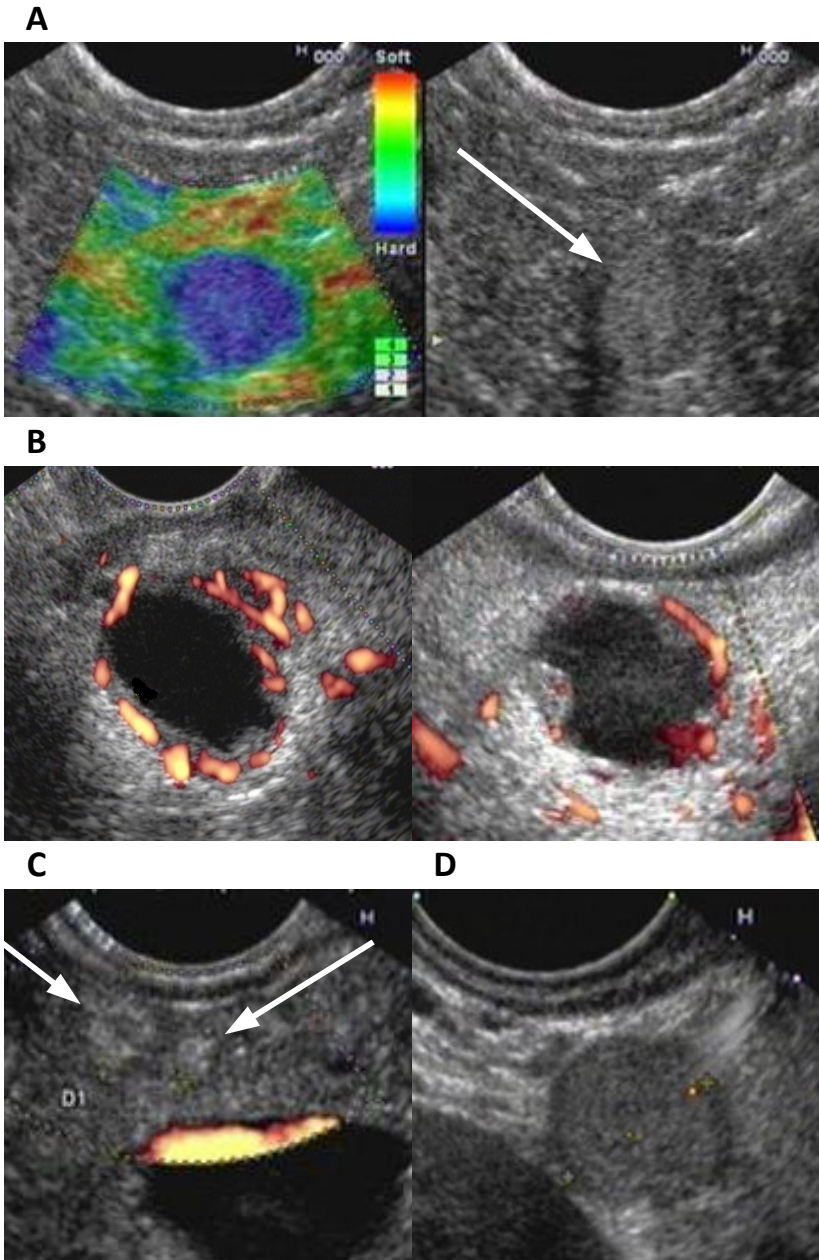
EUS images of pancreatic lesions. A Elastography image of a pancreatic solid lesion (arrow). Blue color indicates rigidity. B Pancreatic cystic lesions with a thick hypervascular wall. Flow is present based on power Doppler, which indicates hypervascularity. C Two solid hyperechoic pancreatic lesions (arrows). D Pancreatic solid lesion with halo phenomena (black surrounding).
